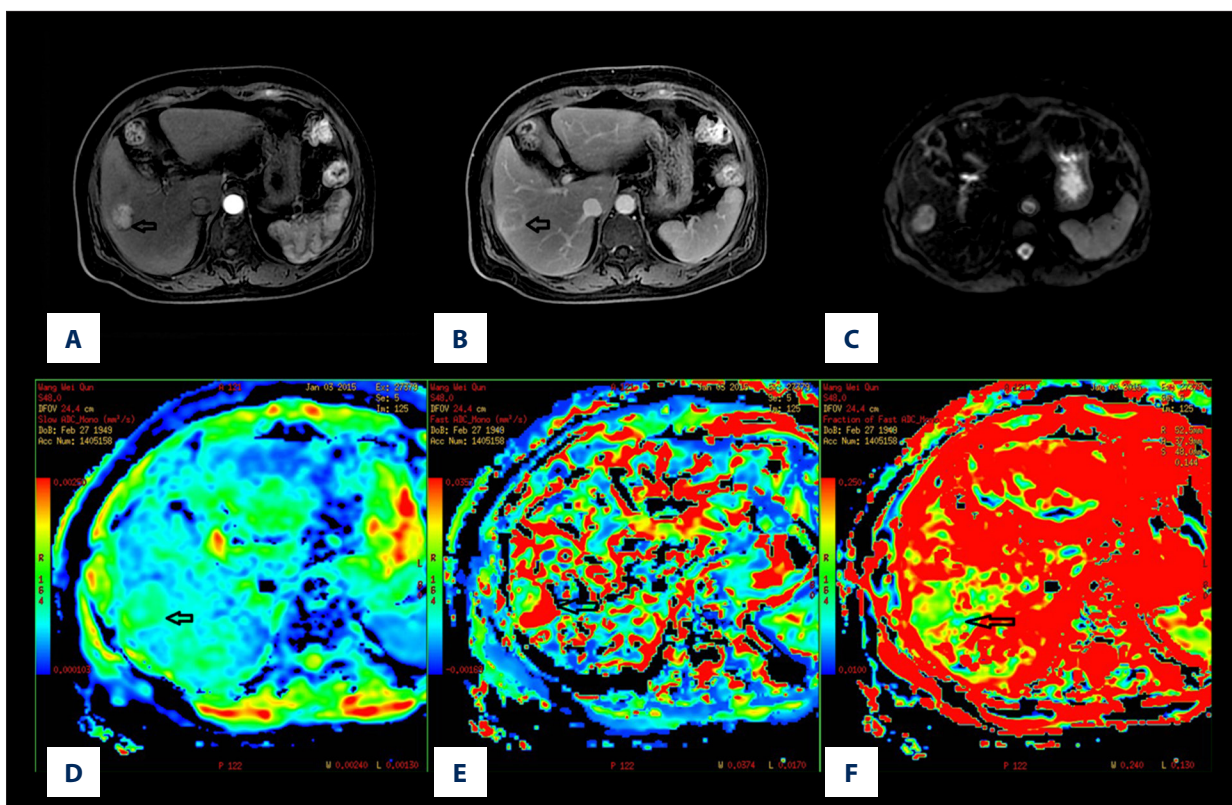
A 63-year-old male man with primary hepatocellular carcinoma. (A) Contrast-enhanced DWI during the arterial phase showing lesion enhancement in segment IV of the liver. (B) The lesion enhancement degree in the delayed phase decreases obviously compared to that of the arterial phase. (C) The signal of the lesion is slightly higher than hepatic parenchyma when $b=0$ s/mm². (D) Mapping of the estimated value of the D parameter. The average value in the lesion ROI was $D=1.19 \times 10^{-3}$ mm²/s. The signal of the lesion is slightly lower than hepatic parenchyma. (E) Mapping of the estimated value of the D* parameter. The average value in the lesion ROI was $D^*=22.4 \times 10^{-3}$ mm²/s. The signal of the lesion is slightly lower than hepatic parenchyma. (F) Mapping of the perfusion-related diffusion fraction (f) with a value of 12.2%.
